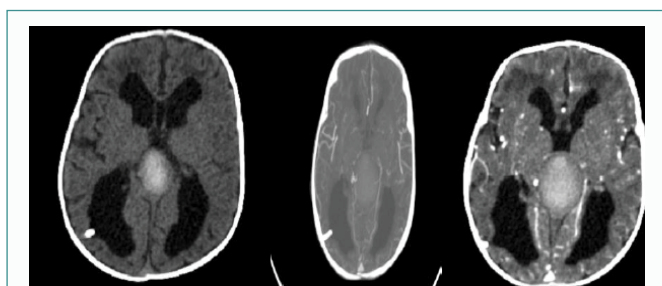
Post-operative (2nd day) CT scan Brain plane and angiography axial view show intra pontomesencephalic colloid cyst and the tip of the shunt and less ventriculomegaly.
